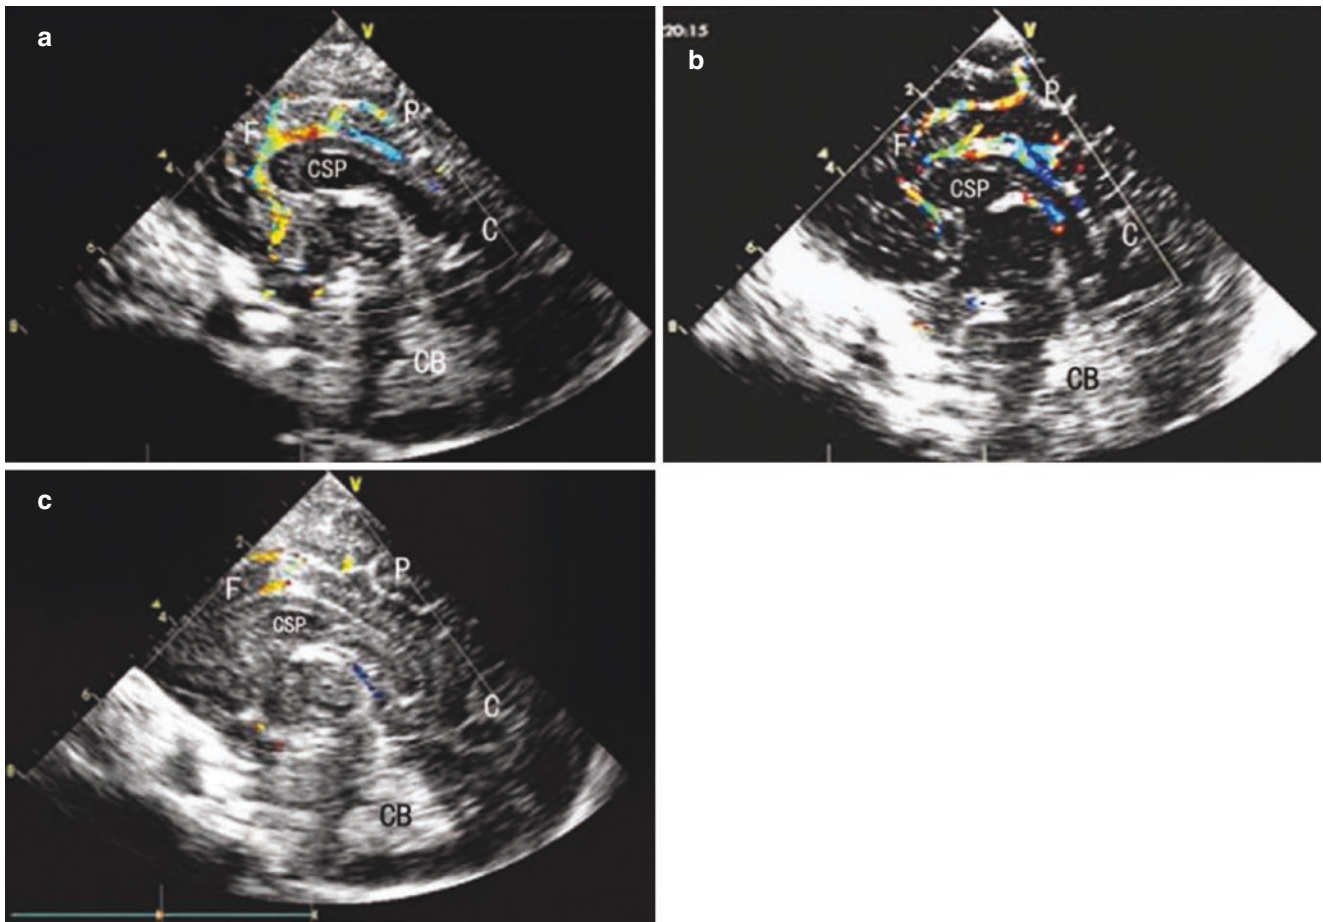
Doppler imaging of the fetal cerebral artery and vein
